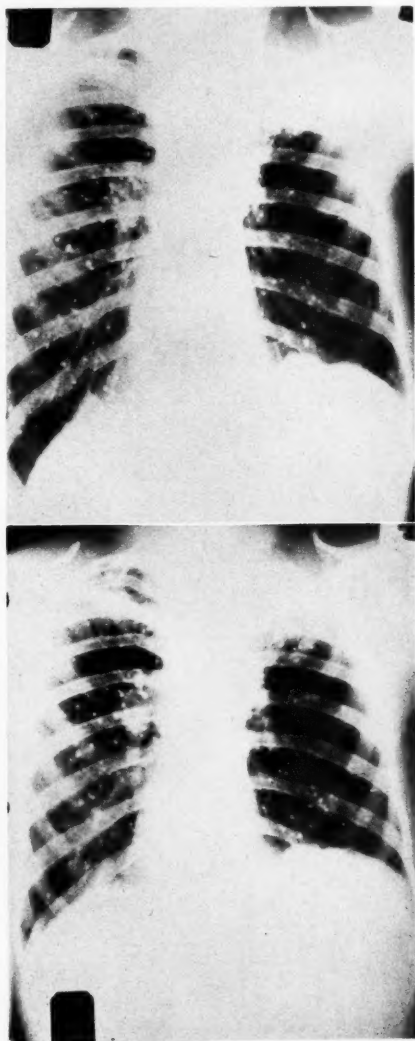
Stereoscopic X-ray view of patient with disseminated nodular tuberculosis, after exhalation (raising the diaphragm). The contents appear to be posterior.
